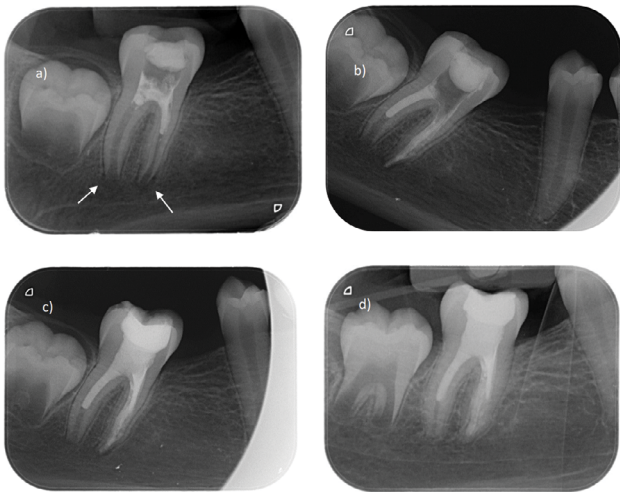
Thickening of the canal walls, continuation of root development and closure of the apical opening. a) Initial condition with osteolytic lesion (arrows). The patient was referred after emergency treatment and application of calcium hydroxide; b) Radiography immediately after revascularization; c) Control after 6 months; d) Follow-up after 18 months, showing thickening of the canal walls, continued root development, closure of the apex in the distal root, and healing of the periapical lesion around the mesial root.
